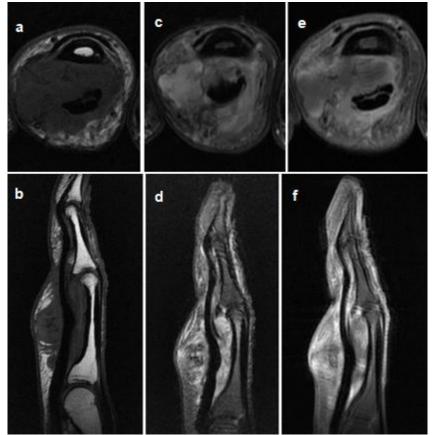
MRI of the hand in axial and sagittal T1-weighted images (a,b), T2-weighted images (c,d) and T1 Fat Sat weighted images after gadolinium injection (e,f)
